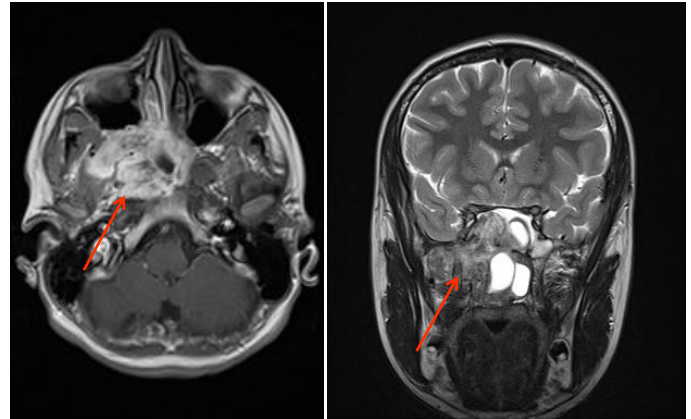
Juvenile angiofibroma stage IIIA on the right side (arrow) – magnetic resonance imaging.
